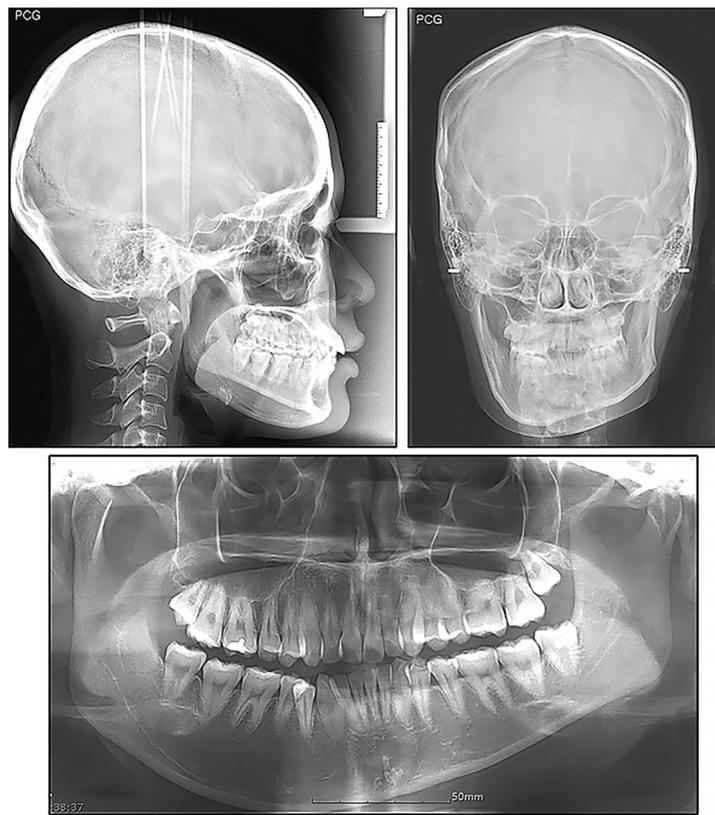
Pretreatment radiographs. Lateral and posteroanterior cephalograms and panoramic radiographs are shown.
